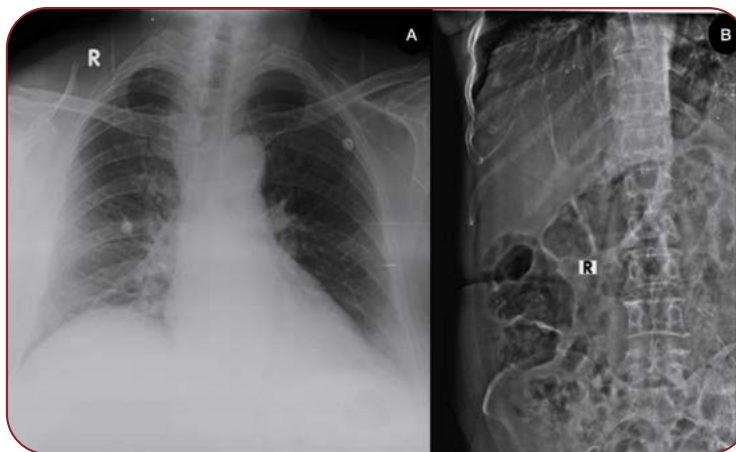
Case 3 radiographs: (A) chest X-ray (PA view) showing right hemidiaphragm elevation; and (B) erect abdominal radiograph demonstrating colonic interposition beneath the right hemidiaphragm, supporting Chilaiditi's sign/syndrome in the clinical context
